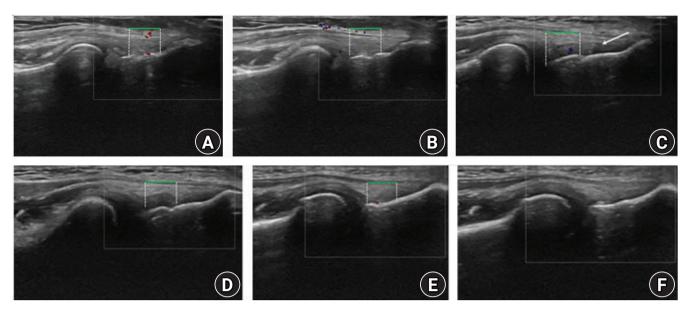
The ultrasonographic follow-up of the three groups. (A) Group 1 at initial. Color Doppler activity (CDA), grade 2; common extensor tendon depth (CETD), 4.3. (B) Group 1 at 12 weeks. CDA, grade 2; CETD, 4.4 mm. (C) Group 2 at initial. CDA, grade 2; CETD, 4.2 mm. White arrow indicates a suspicion of a partial thickness tear of the common extensor tendon. (D) Group 2 at 12 weeks. CDA, grade 1; CETD, 4.5 mm. (E) Group 3 at initial. CDA, grade 1; CETD, 3.8 mm. (F) Group 3 at 12 weeks. CDA, grade 0; CETD, 4.0 mm.
